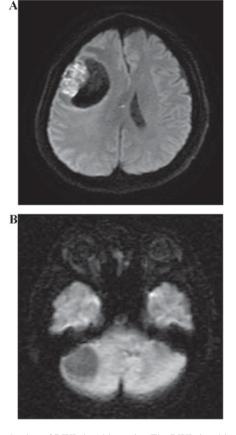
Evaluation of DWI signal intensity. The DWI signal intensity was evaluated in the solid portion of the tumor in five stages as follows: 5, higher compared with the cortex; 4, iso to the cortex; 3, higher compared with the white matter; 2, iso to the white matter; and 1, lower compared with the white matter. (A) This lesion existed in the high signal intensity solid portion and low signal cystic portion on DWI, and the signal intensity was classified as grade 5. (B) This lesion was solid on the contrast enhanced T1-weighted image, and demonstrated lower signal intensity compared with the white matter on DWI; the signal intensity was classified as grade 1. DWI, diffusion weighted image.
